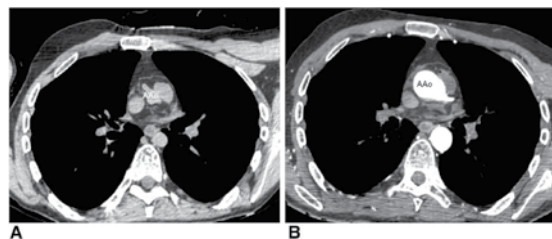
Effect of postmortem perfusion on the vascular system. (A) Unenhanced CT scan revealing collapsed ascending aorta (AAo). (B) Arterial phase of CT angiography showing the AAo expanded and filled with contrast agent (white).
